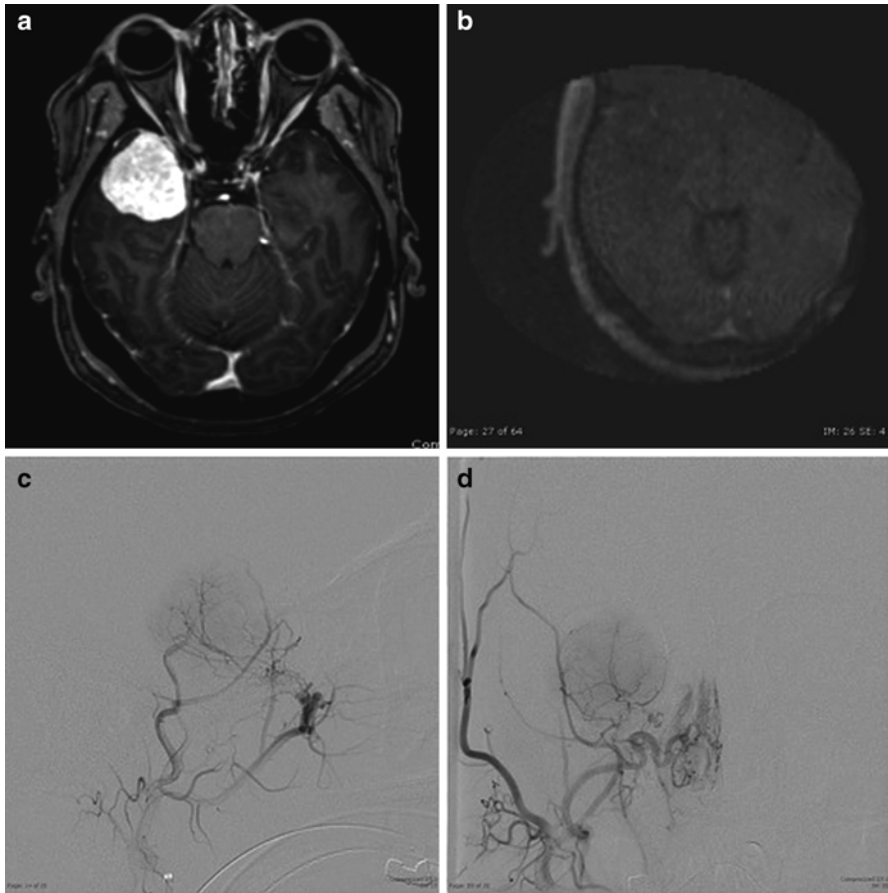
Gadolinium-enhanced axial image showing avid enhancement of a right middle fossa meningioma (a). Catheter angiography demonstrates a significant tumor blush with microcatheter injection of the internal maxillary artery on anterior–posterior (b) and lateral (c) projections. No residual enhancement is seen on intraoperative gadolinium-enhanced MRI (d)
